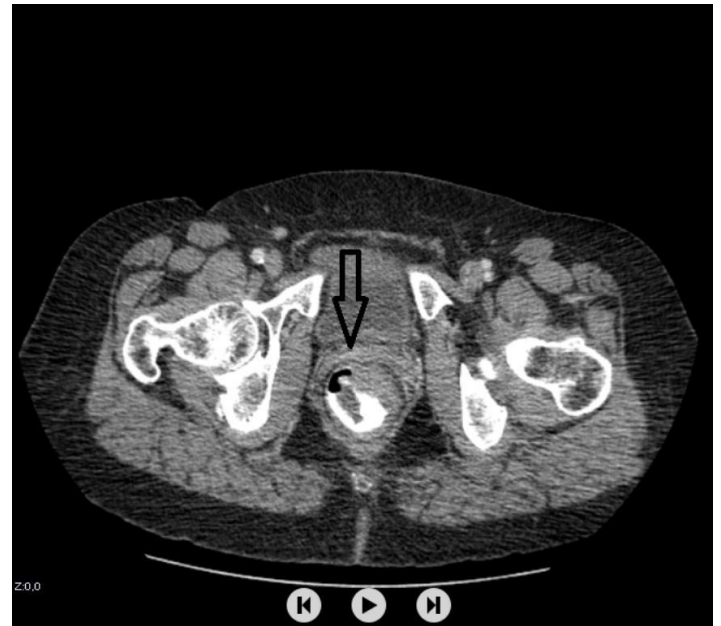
Computed tomography image of anorectal malignant melanoma.
